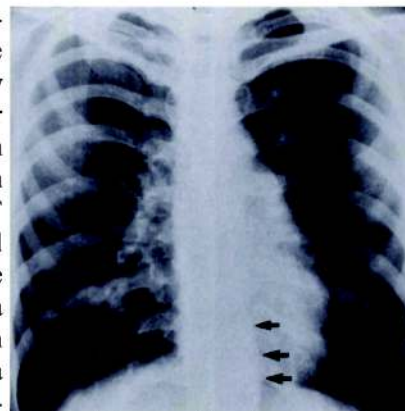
Wavy or scalloped appearance of the descending thoracic aorta in chest radiograph
